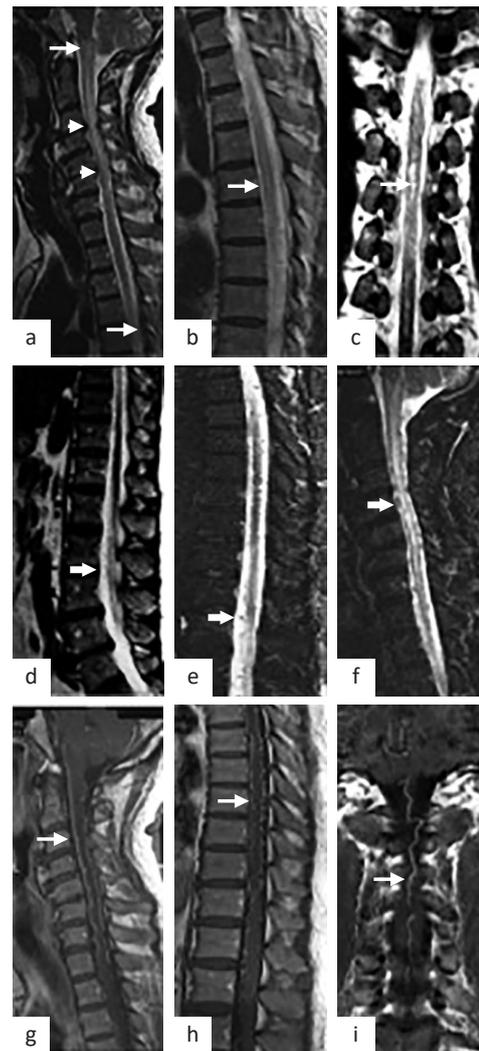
Spinal cord MRI. Spinal cord T2-weighted MRI sequence showing hyperintensity starting from the CMJ down to T6 (thin arrows) (a-c); cervical spondylosis was seen (white arrowheads), but not significant as the cause of the current symptoms. Numerous flow voids with edema and swelling along of the spinal cord down to lumbar level (arrows) (d-f). Spinal cord sagittal (g and h) and coronal (i) gadolinium-enhanced T1-weighted sequence showing enlargement of the spinal veins in the anterior and posterior epidural space (thin arrows). CMJ=cervicomedullary junction; MRI=magnetic resonance imaging
